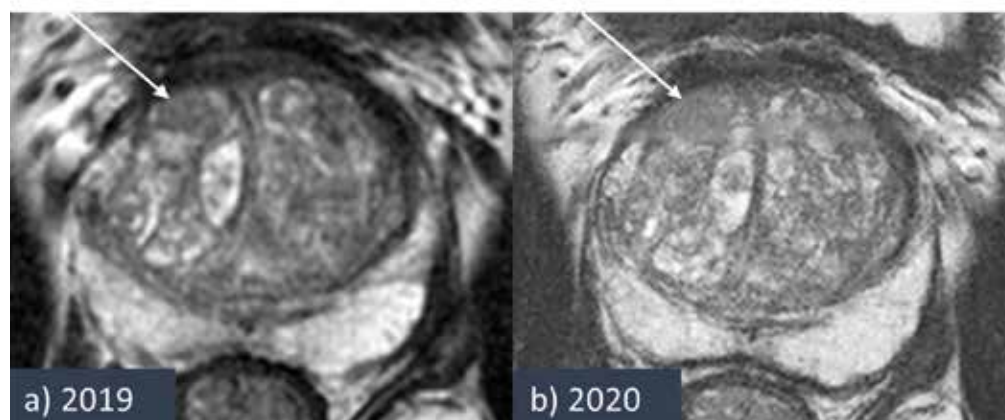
Tumour-suspicious lesion on MRI (a) at diagnosis in 2019 (white arrow) where targeted biopsies showed GG1 PCa with 6 mm maximum cancer core length (MCCL). The patient went on AS and confirmatory MRI after one year (b) showed revealed tumour-growth (larger lesion) with a more homogenous appearance and lower ADC-value. Repeated targeted biopsy showed upgrading to GG 2 with MCCL 9 mm.
